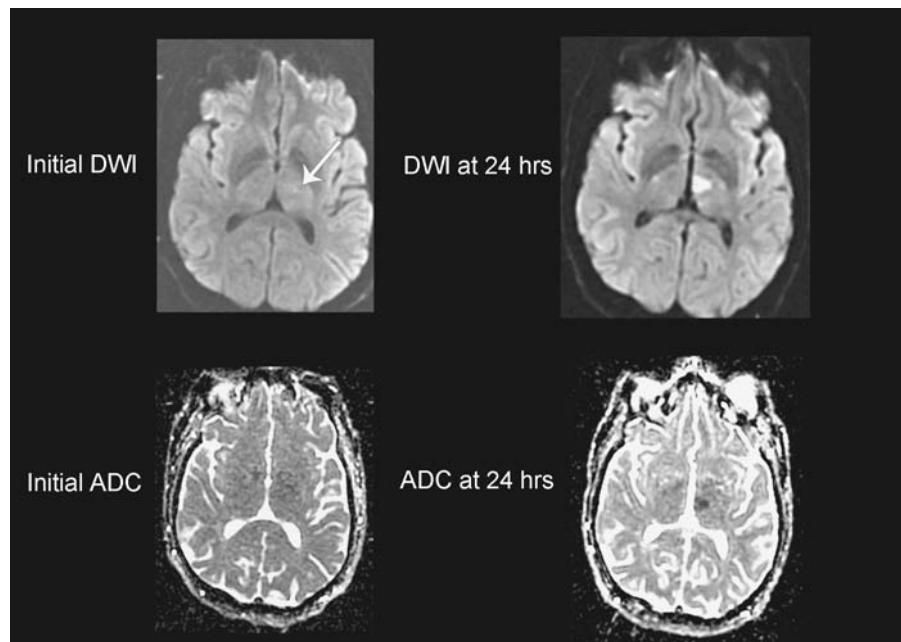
Thalamic lacune “without an acute DWI abnormality.” Forty-seven-year-old male with sensory loss, imaged at 1.5 hours after symptom onset. Initial DWI and ADC images were interpreted as demonstrating no definite acute infarction. In retrospect, there is a punctate left thalamic DWI hyperintense lesion (*arrow*). Follow-up DWI and ADC images clearly demonstrate a left thalamic lacunar infarction. Abbreviations: DWI, diffusion-weighted images; ADC, apparent diffusion coefficient.
